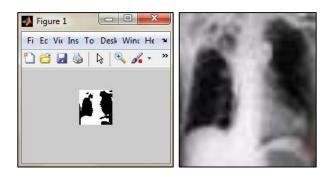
X-ray film of a lung with COPD and its binary image
